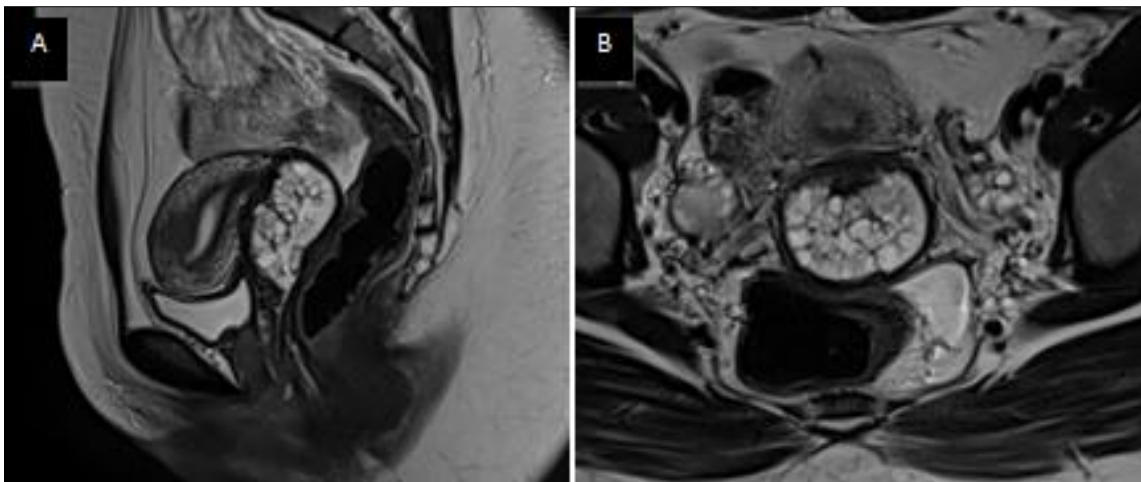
Sagittal (A) and axial T2 (B) weighted MRI of the pelvis showing multiple nabothian cysts which in T2 hyperintense
